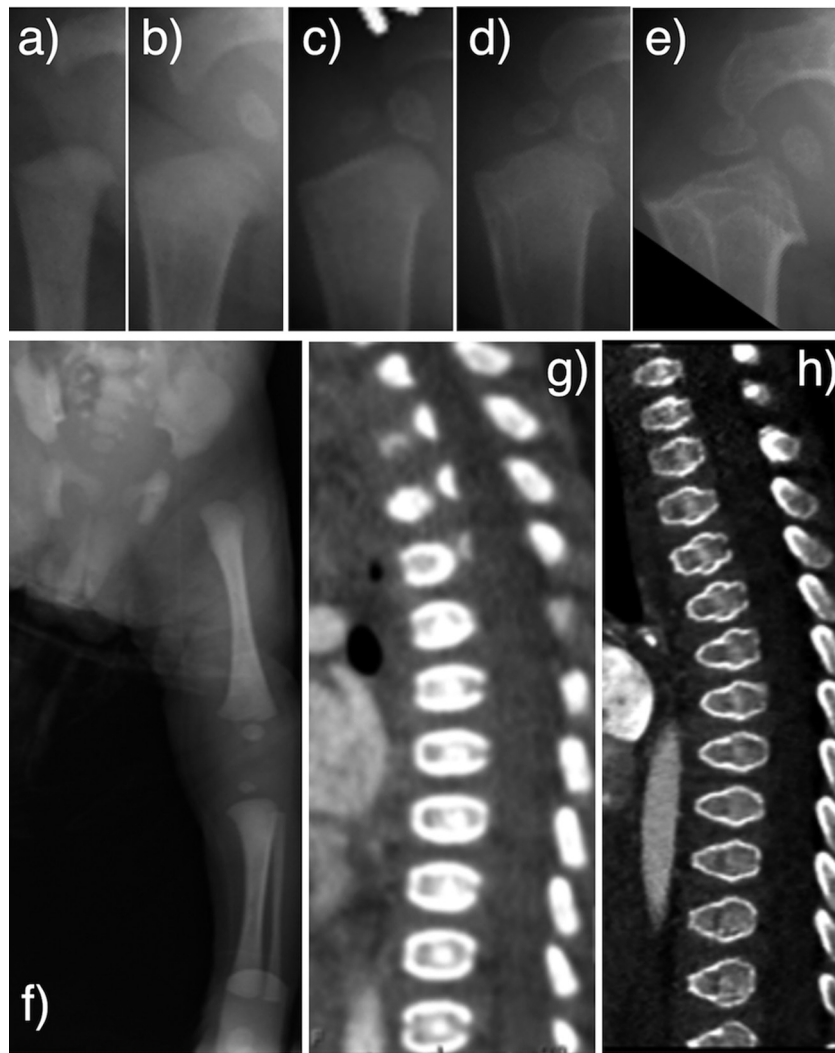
Sequential skeletal changes in Patient 5. A proximal metaphyseal change in the right humerus (a: 1 d; b: 4 mo, c: 7 mo; d: 10 mo; e: 22 mo) was not obvious before 7 mo of age, but was gradually obvious after 10 mo of age. The appearance of the epiphyseal nucleus was delayed, and segmentation was observed after 7 mo of age. Metaphyseal changes in the left femur, tibia, and fibula were not obvious at 10 d of age (f). Chest computed tomography shows that the shape of the vertebral body was normal at 3 mo of age (g), but anterior tonguing became obvious at 23 mo of age (h).
